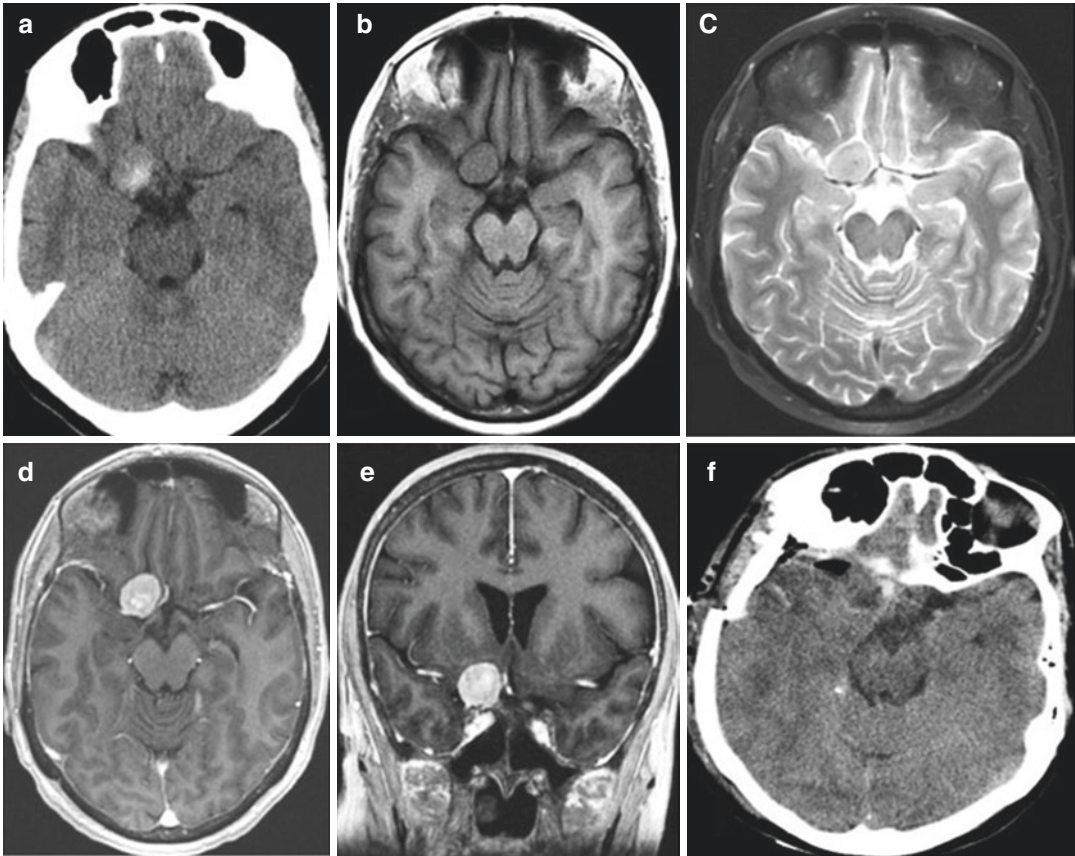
Right anterior skull base meningioma in a 60-year-old woman. The patient presented with a headache. Neurological examination was normal. Preoperative CT scan (a) and T1- and T2-weighted MRIs (b, c) and T1-weighted axial and coronal MRIs with contrast (d, e)
